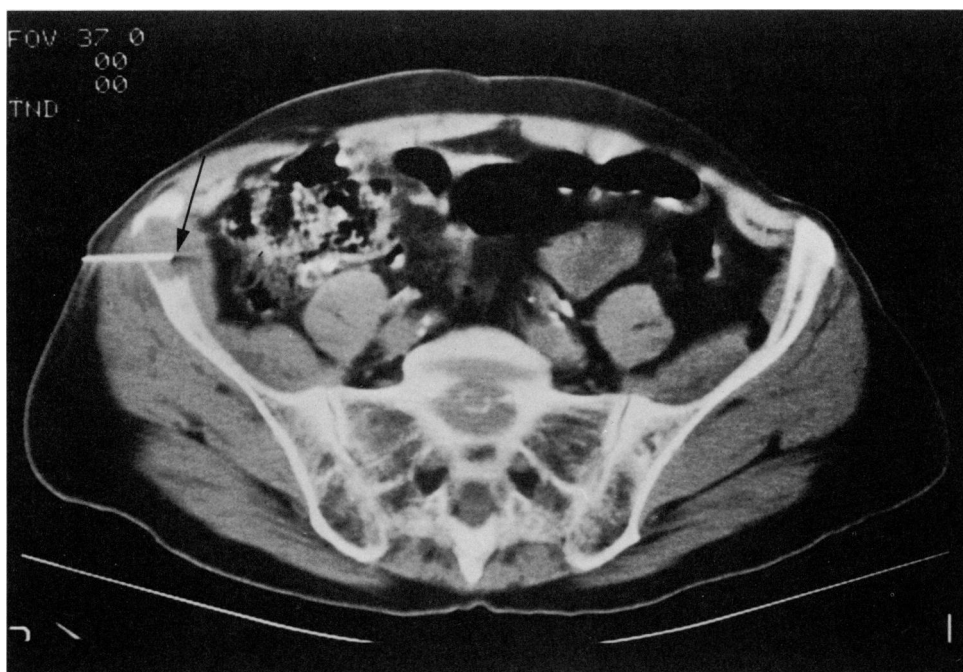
CT scan showing needle tip (*arrow*) in destructive right ileum lesion of patient with an unknown primary. Cytology revealed poorly differentiated adenocarcinoma from a lung primary.
